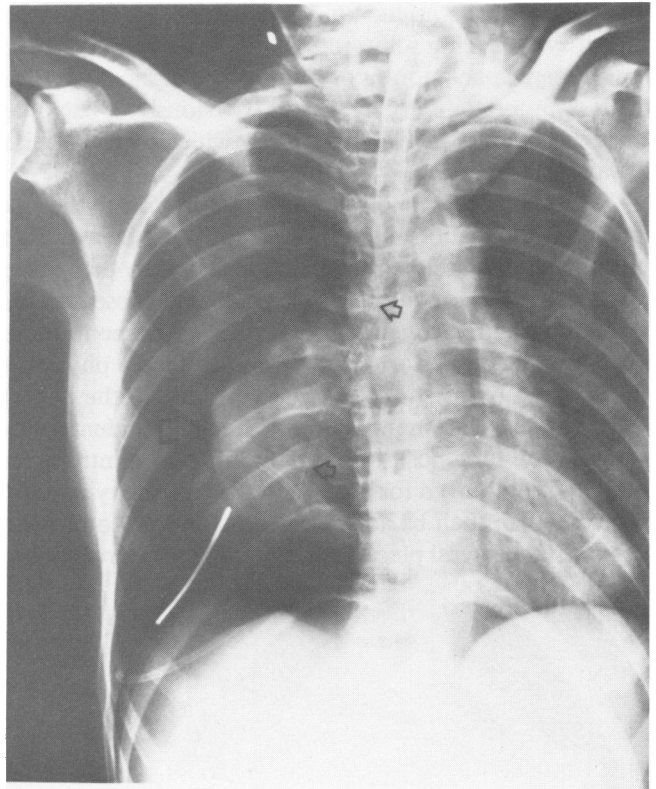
Chest x-ray reveals complete right-sided pneumothorax (large arrow) with feeding tube (small arrows) passing down right mainstem bronchus into the pleural space.
